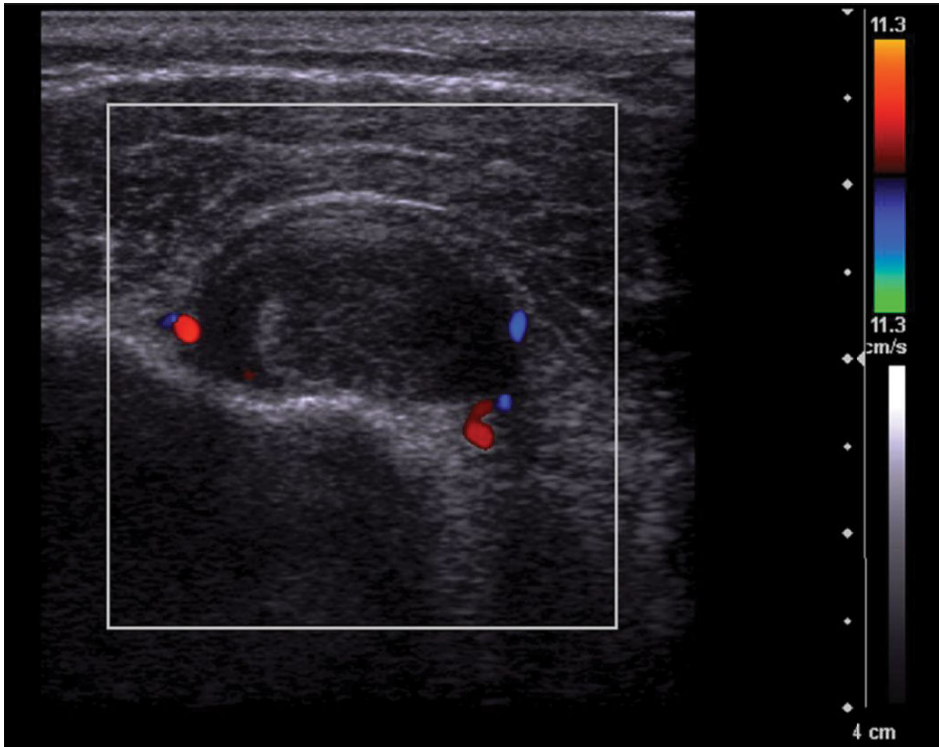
Doppler ultrasound image — tenosynovial giant cell tumor of the knee.
